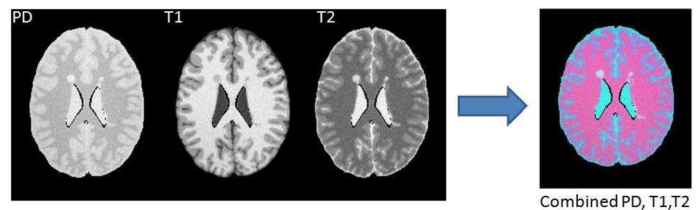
T1-w, T2-w, and PD-w MRI gray images and the combined color image.
